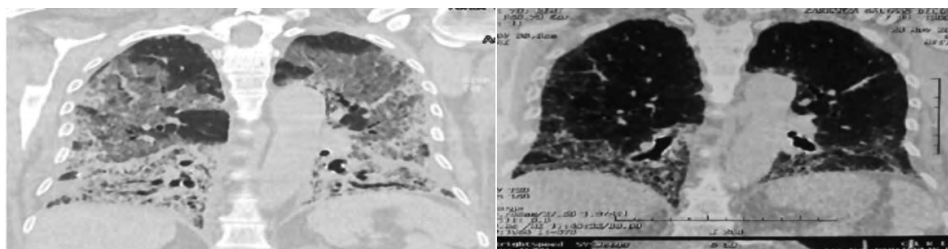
CT note the decrease in opacities in upper lung lobes in the coronal section 18 months after treatment with pirfenidone
